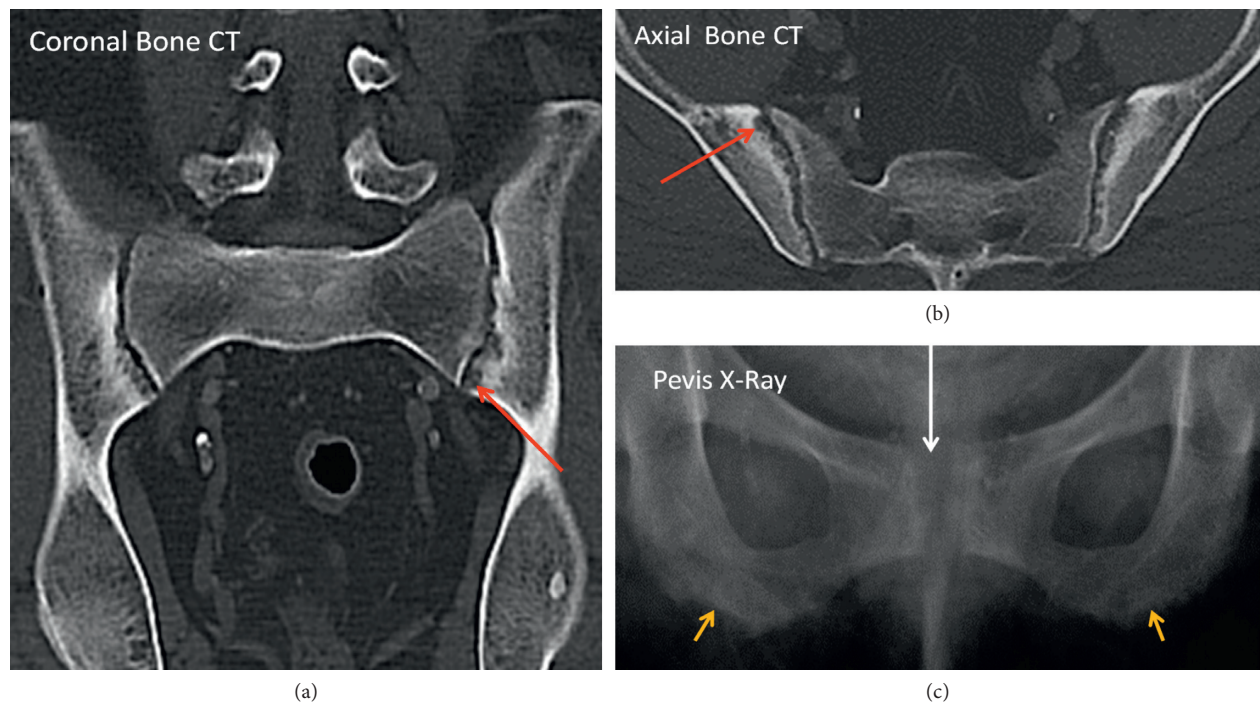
Subchondral resorption of the sacroiliac joints. Coronal and axial CT images show areas of subchondral lucency with irregular articular margin (red arrows), apparent widening of the joint space and surrounding hyperdense sclerosis. Pelvis X-ray symphysis pubis subchondral resorption (white arrow) with widening and also subligamentous resorption of the ischial tuberosities (yellow arrows). (a) Coronal bone CT. (b) Axial bone CT. (c) Pelvis X-ray.
